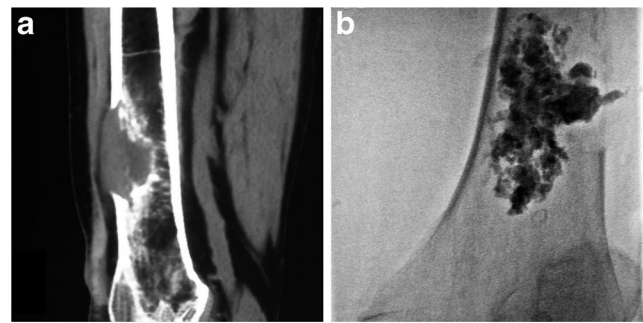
Metastasis of right distal femur in a 55-year-old male patient with right leg pain and disability. (A) An osteolytic lesion is depicted in the right distal femur on a sagittal CT image. (B) Radiograph obtained after percutaneous long bone cementoplasty (PLBC) shows good distribution of bone cement in the lesion of the femur
